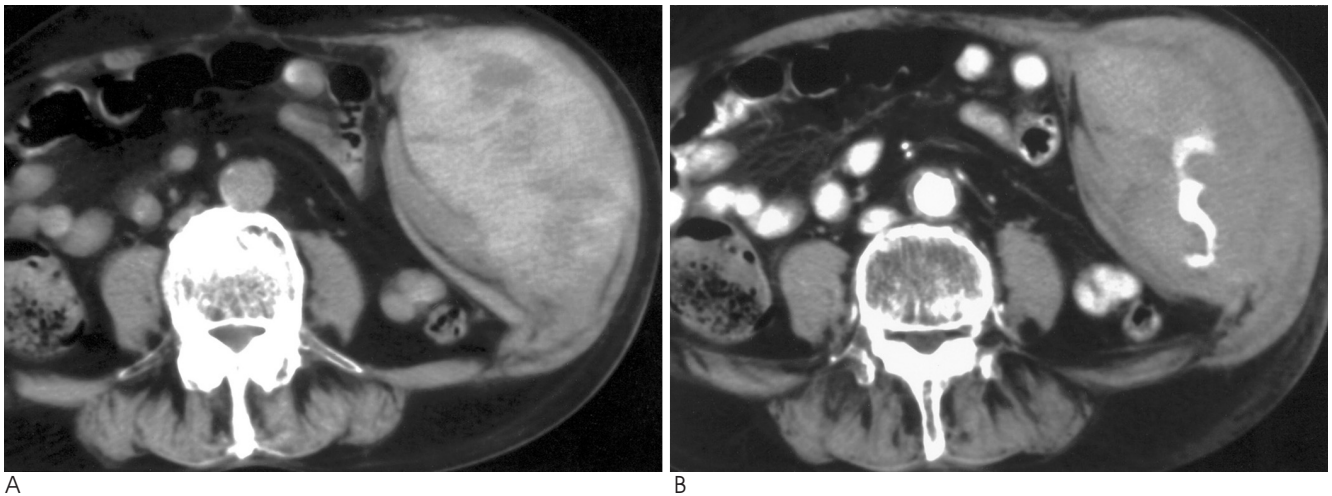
Pre- (A) and post-enhanced CT scan (B) show a large hematoma in the left anterolateral abdominal wall and extravasation of contrast material in the hematoma. The left deep circumflex iliac artery (arrow) and the left inferior epigastric artery (arrowhead) are noted on the lower level scan (C), which are branches of the left external iliac artery. The vessels were seen along the posterior margin of the hematoma.
